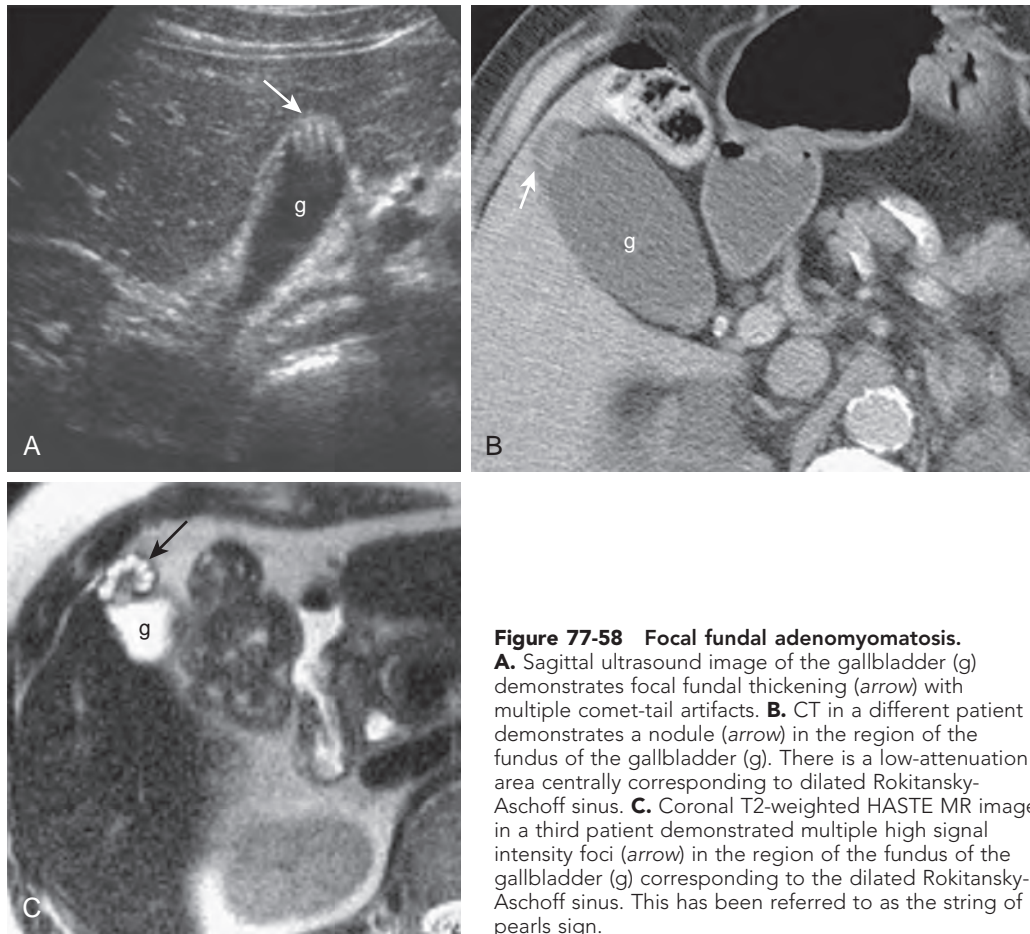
Focal fundal adenomyomatosis. A. Sagittal ultrasound image of the gallbladder (g) demonstrates focal fundal thickening (arrow) with multiple comet-tail artifacts. B. CT in a different patient demonstrates a nodule (arrow) in the region of the fundus of the gallbladder (g). There is a low-attenuation area centrally corresponding to dilated Rokitansky-Aschoff sinus. C. Coronal T2-weighted HASTE MR image in a third patient demonstrated multiple high signal intensity foci (arrow) in the region of the fundus of the gallbladder (g) corresponding to the dilated Rokitansky-Aschoff sinus. This has been referred to as the string of pearls sign.
